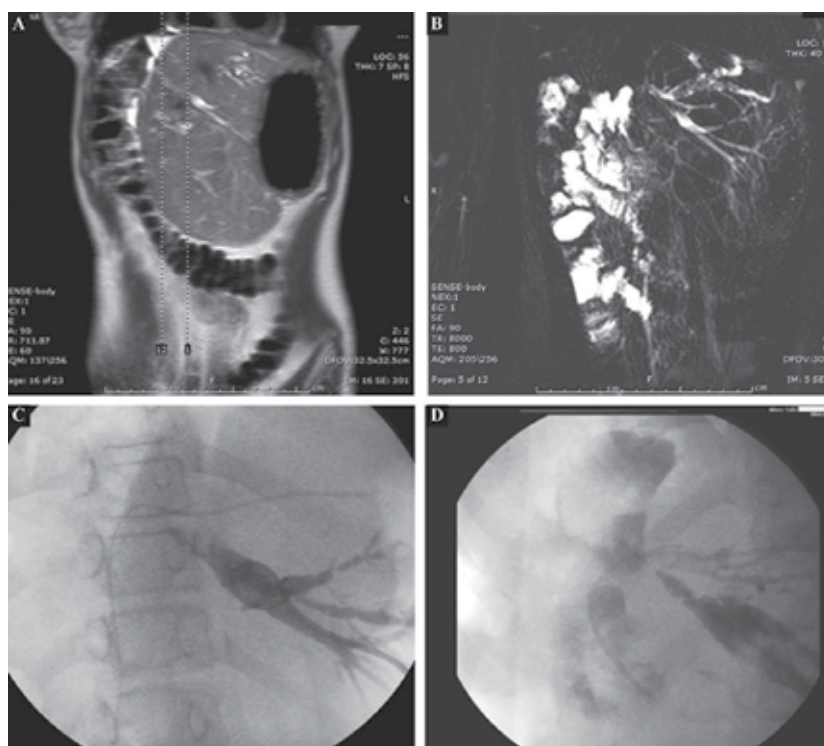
Sharp recanalization of occlusive hepatico-jejunostomy. (A&B) MRI coronal images and MRCP demonstrating two separate hepatico- jejunostomy with multiple filling defects in the superior bile duct. (C) Cholangiogram demonstrated external drain in the lower segmental bile duct with total occlusion of the inferior anastomosis, a plastic stent is noted across the superior anastomosis. (D) S/p sharp recanalization of the inferior anastomosis with the contrast drained through the anastomosis into the jejunum
